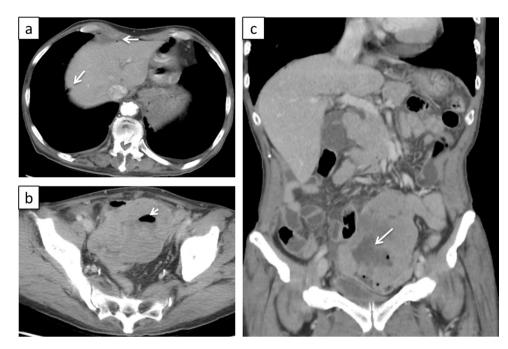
Computed tomographic scans, showing (a) free air at the liver surface and the gastric cardia with fluid collection (white arrows) and (b, c) a solid mass within the pelvis, measuring approximately 14 cm × 7 cm, with some air (short arrows) and internal liquid (long arrows).
